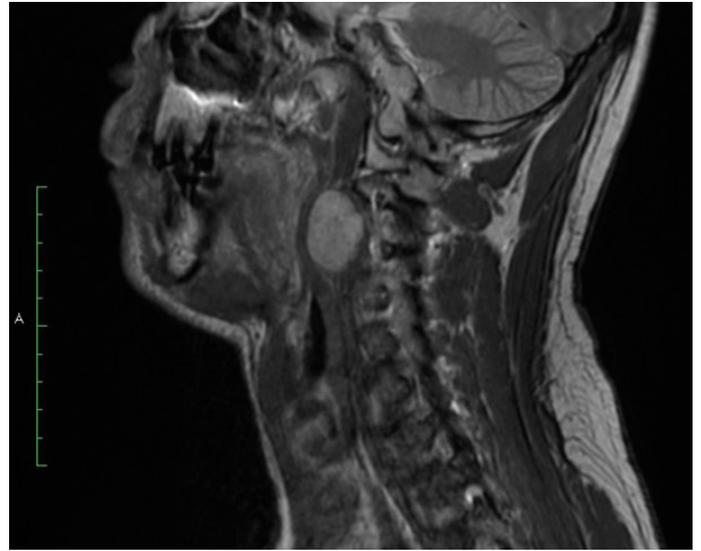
Sagittal MR of the head in the T2-weighted sequence after contrast administration – tumor of the posterior pharyngeal wall.
